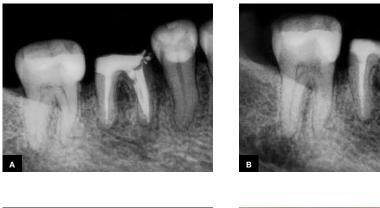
A) Control radiograph, filling of canal MV and repair of lesioned areas. 4/15/2004. B) Control Radiograph 12/29/2005.
